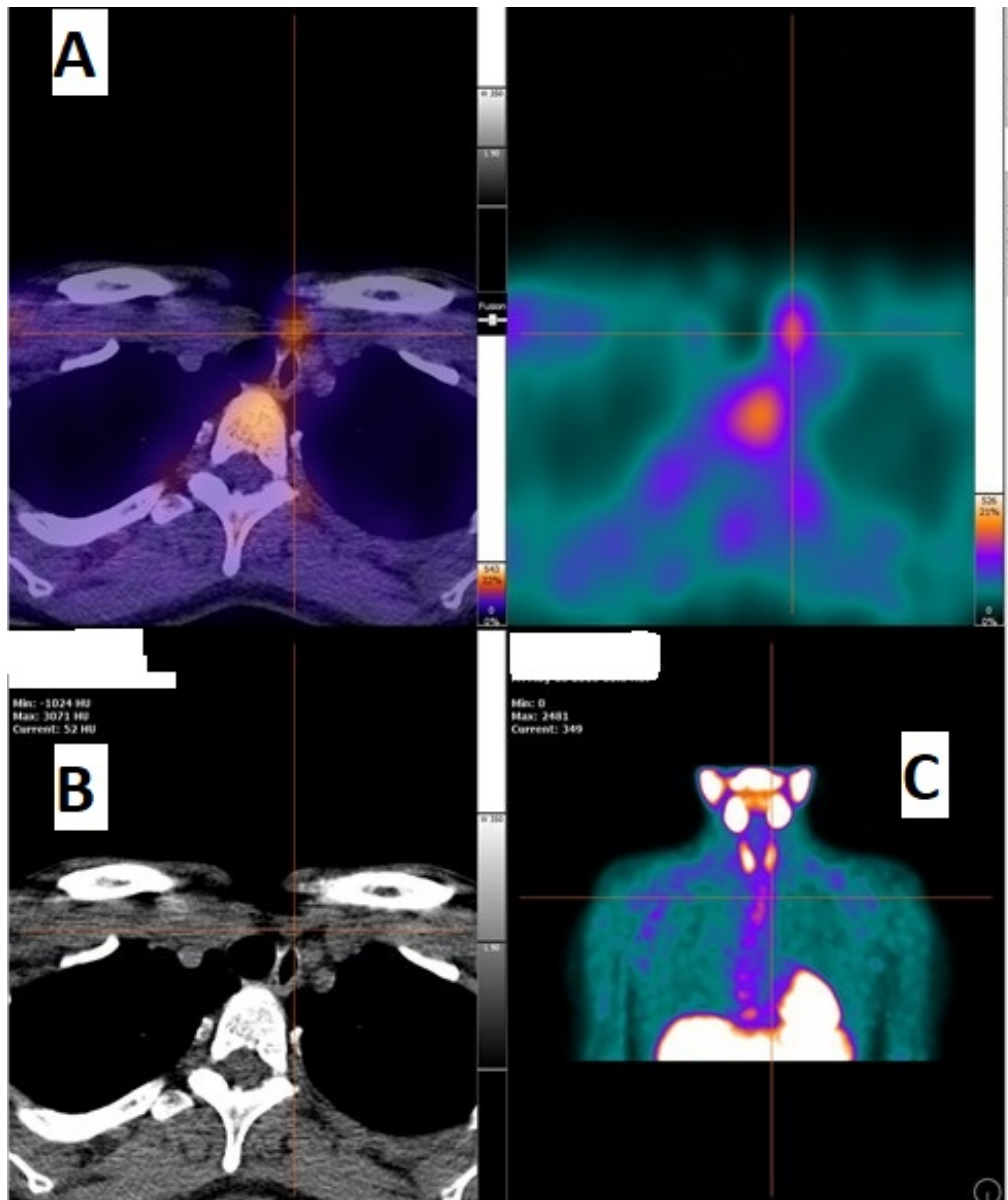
Case 3: Additional scans that allow better localization of the parathyroid gland relative to the surrounding anatomical structures. (A) Coronal view computed tomography scan with fused imaging of non-contrast CT and Tc-99m sestamibi. (B) Axial view of scintigraphy. (C) Coronal view of scintigraphy with Tc-99m sestamibi.
